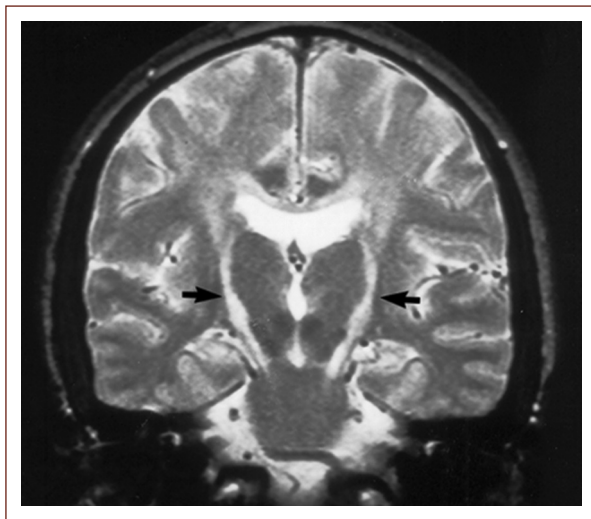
Magnetic resonance imaging coronal T2-weighted sequence showed high intensity signal in the pyramidal tract (arrows). The hyperintense signal started in frontal motor cortices.
